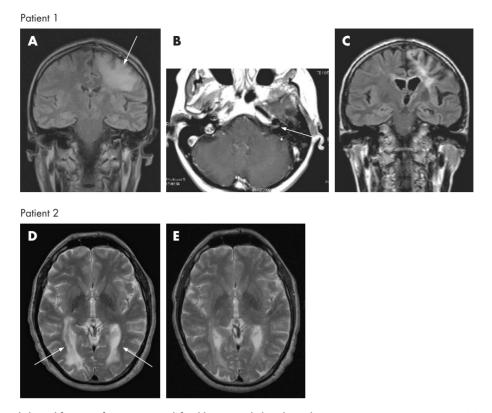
Neuroradiological features of progressive multifocal leucoencephalopathy on brain magnetic resonance imaging. (A) Patient 1: on this coronal slice (fluid-attenuated inversion recovery), there is a large hyperintensity in the left frontal white matter that extends into the internal capsule (arrow). No mass effect or contrast enhancement is present. (B) The left facial (VII) and vestibulocochlar (VIII) bundle enhances after contrast administration on this T1-weighted axial sequence. (C) Compared with (A), 2 years later, the hyperintense lesion has decreased in volume and only subcortical necrosis and atrophy are present. (D) Patient 2: on this T2-weighted axial slice, hyperintense lesions are present along the optic radiations, extending from the thalami to the occipital lobes on both sides (arrows). (E) After treatment, 4 months later, the size and the intensity of these lesions are markedly decreased.
